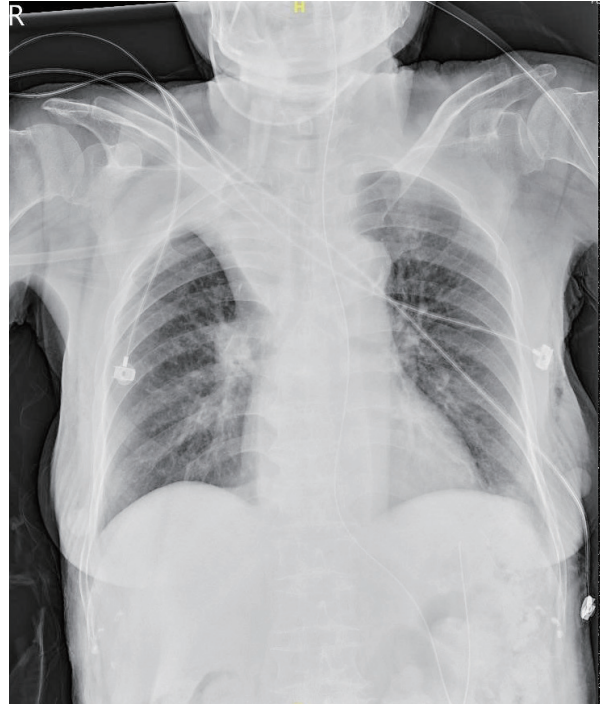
Follow-up chest plain film showed resolution of the subcutaneous emphysema and pneumomediastinum.
